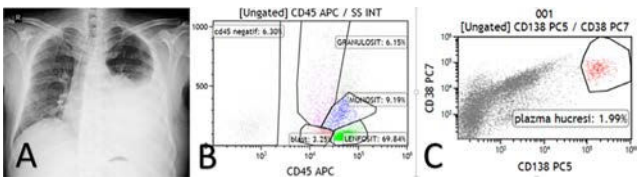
(A) Chest X-ray showed pleural effusion. (B) Pleural fluid was positive for myeloid blasts. (C) Plasma cell percentage of pleural fluid.
